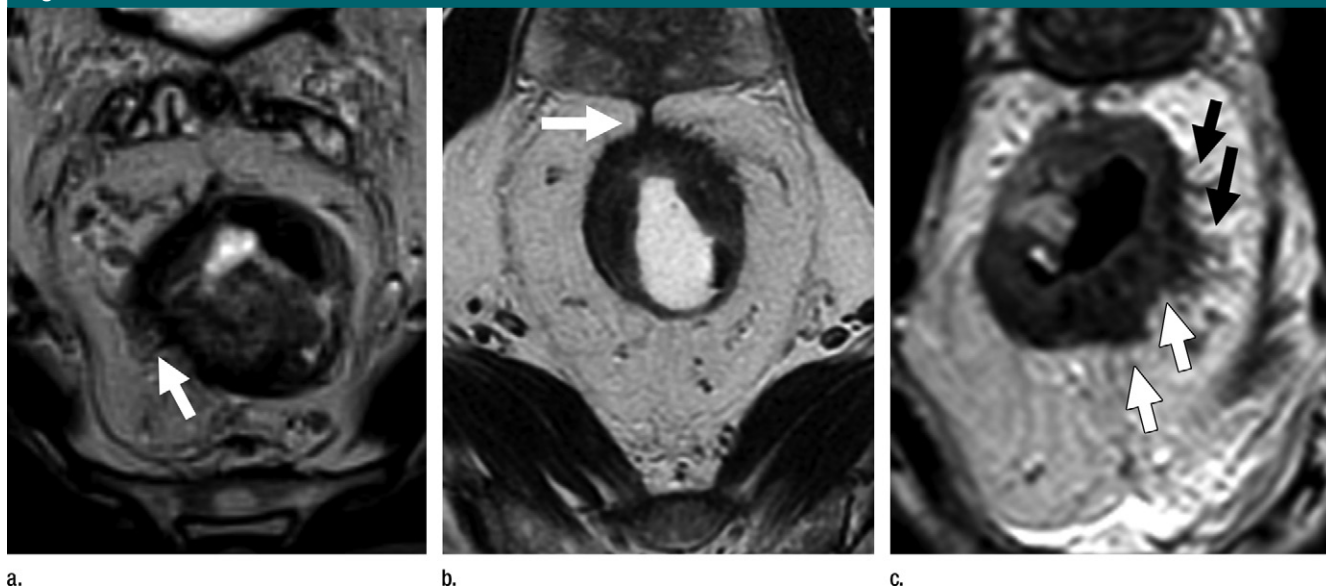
Short-axis axial T2-weighted images show (a) multiple, thin, hypointense linear bands in the mesorectum corresponding to subtle fibrotic scarring (arrow), (b) single, thin, hypointense scar extending to the mesorectal fascia corresponding to a fibrotic reaction (arrow), and (c) a desmoplastic reaction, as seen by the fine low-signal-intensity strands (black arrows) and tumor which appears to be of intermediate signal intensity and more nodular (white arrows).
